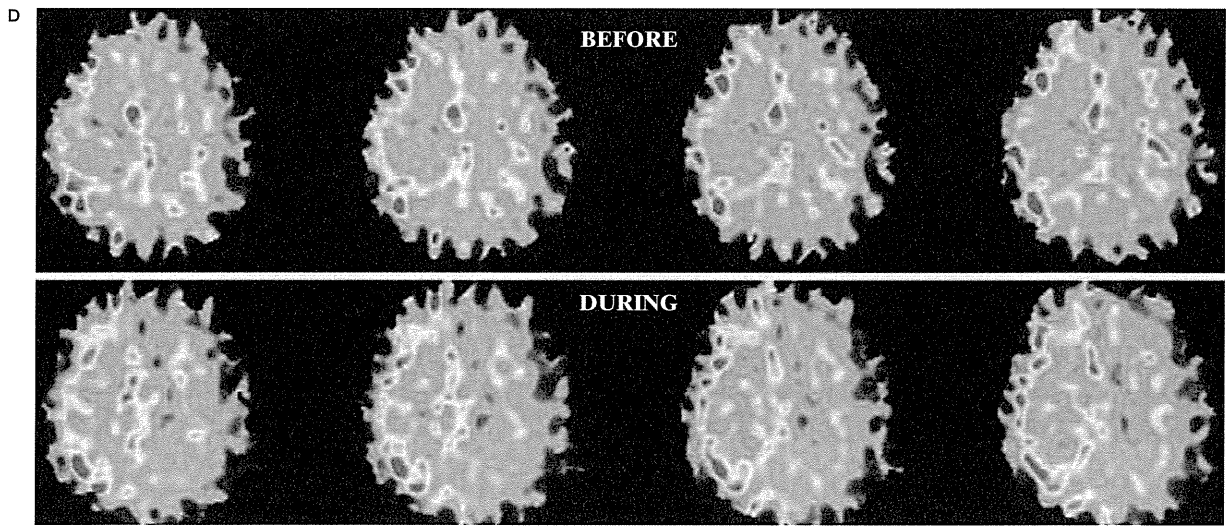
A) 3D-CT angiogram shows a giant cavernous aneurysm. B) During BTO of the right ICA, a mild global decrease in CBF in the bilateral hemispheres is demonstrated by PET study. The CMRO₂ was symmetrical (C) and the OEF in the right MCA territory is slightly increased (D). This patient was considered to be tolerant for permanent ICA occlusion and treated with coil embolization with ICA occlusion (E).
